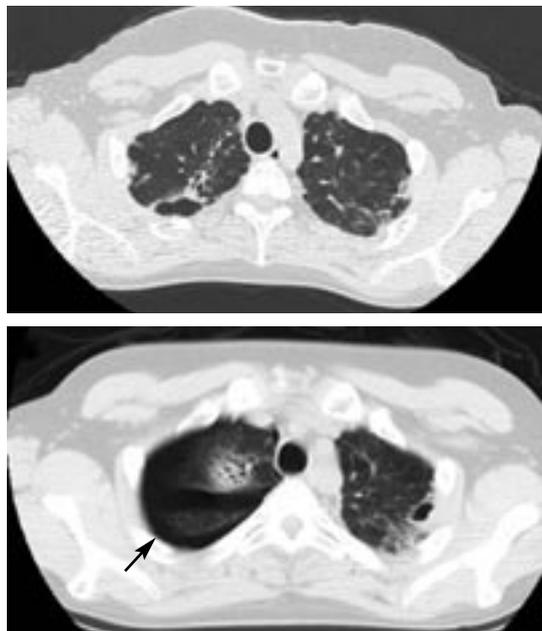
Top, a computed tomographic (CT) scan showing bilateral interstitial changes consistent with pulmonary fibrosis in a patient treated with allogeneic bone marrow transplantation for relapsed acute lymphocytic leukemia. Bottom, A CT scan of the same patient 9 months later shows spontaneous pneumothorax (arrow). Lung biopsy confirmed pulmonary fibrosis.
